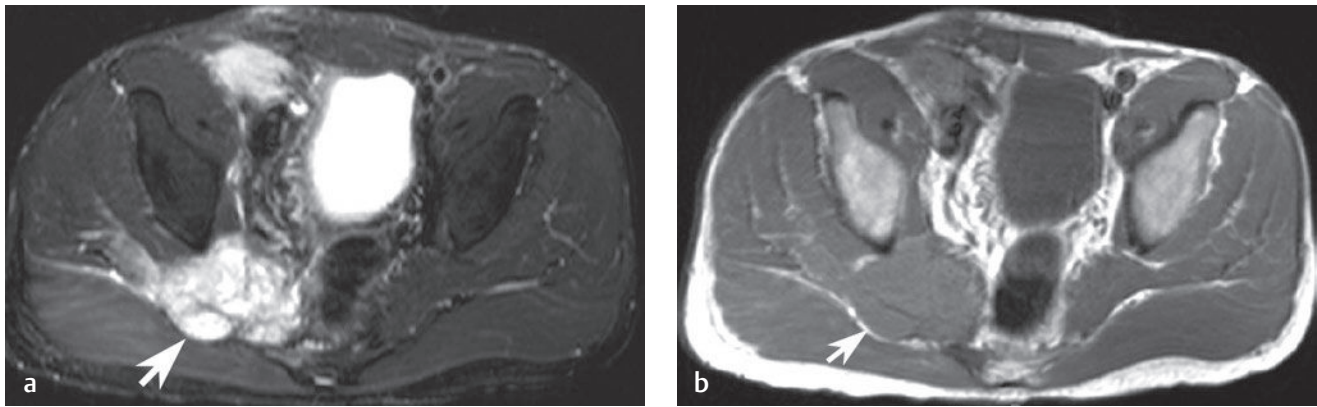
Right-side sacral malignant peripheral nerve sheath tumor. Compared with muscle, the lesion (arrow on each) is (a) hyperintense on an axial fat-suppressed T2-weighted image and (b) isointense on an axial T1-weighted image.[†]
